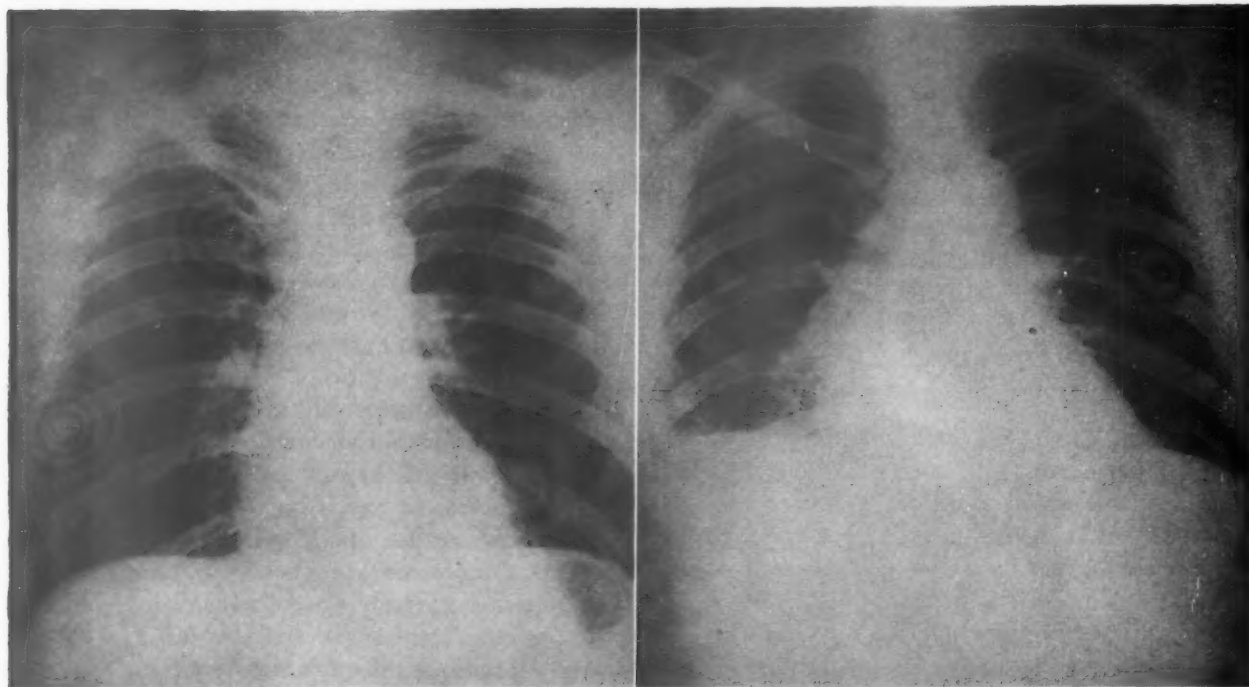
Chest roentgenogram of patient L. H. before (left) and after (right) the hypotensive episode.
